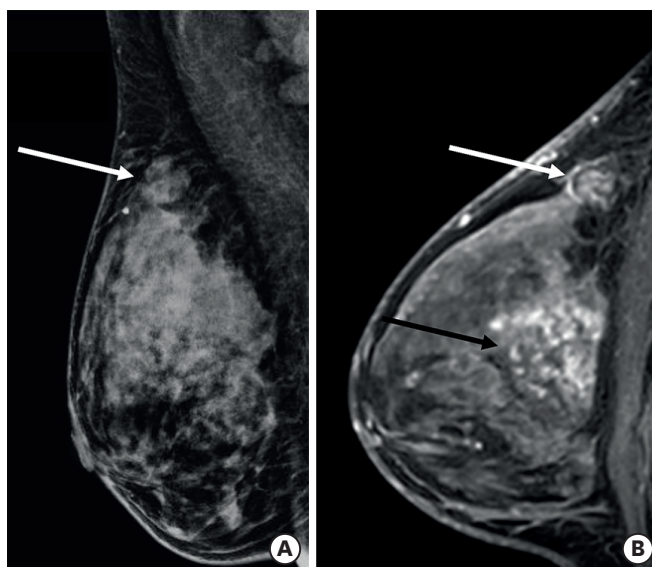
Preoperative images of a 43-year-old woman with biopsy-proven invasive ductal carcinoma of triple-negative subtype. (A) Mammogram shows an oval mass, which represents the index cancer (white arrow). (B) MRI shows an additional 3-cm segmental non-mass enhancement (black arrow) 2-cm lower than the index cancer (white arrow). Second-look ultrasound failed to detect the lesion. MRI-guided biopsy confirmed the fibrocystic changes. The lesion had been stable for more than 2 years. MRI = magnetic resonance imaging.
